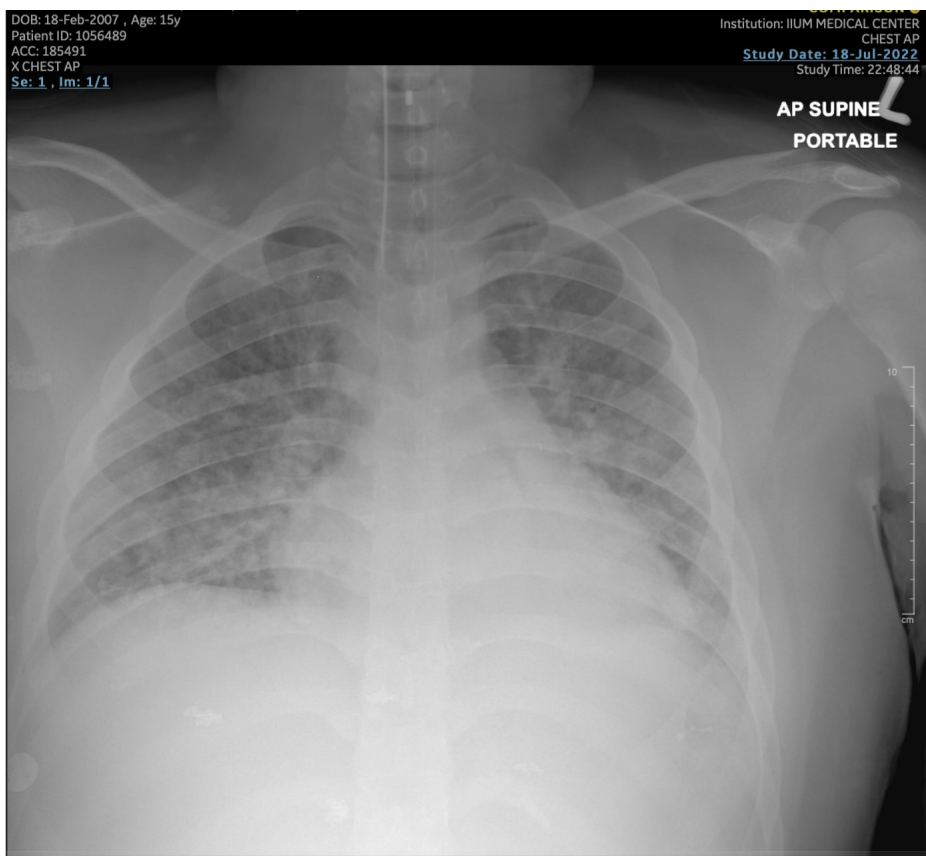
Anterior-posterior view of chest radiograph post-intubation showing bilateral air space opacification with blunted left costophrenic angle on day 1 of ICU admission.
